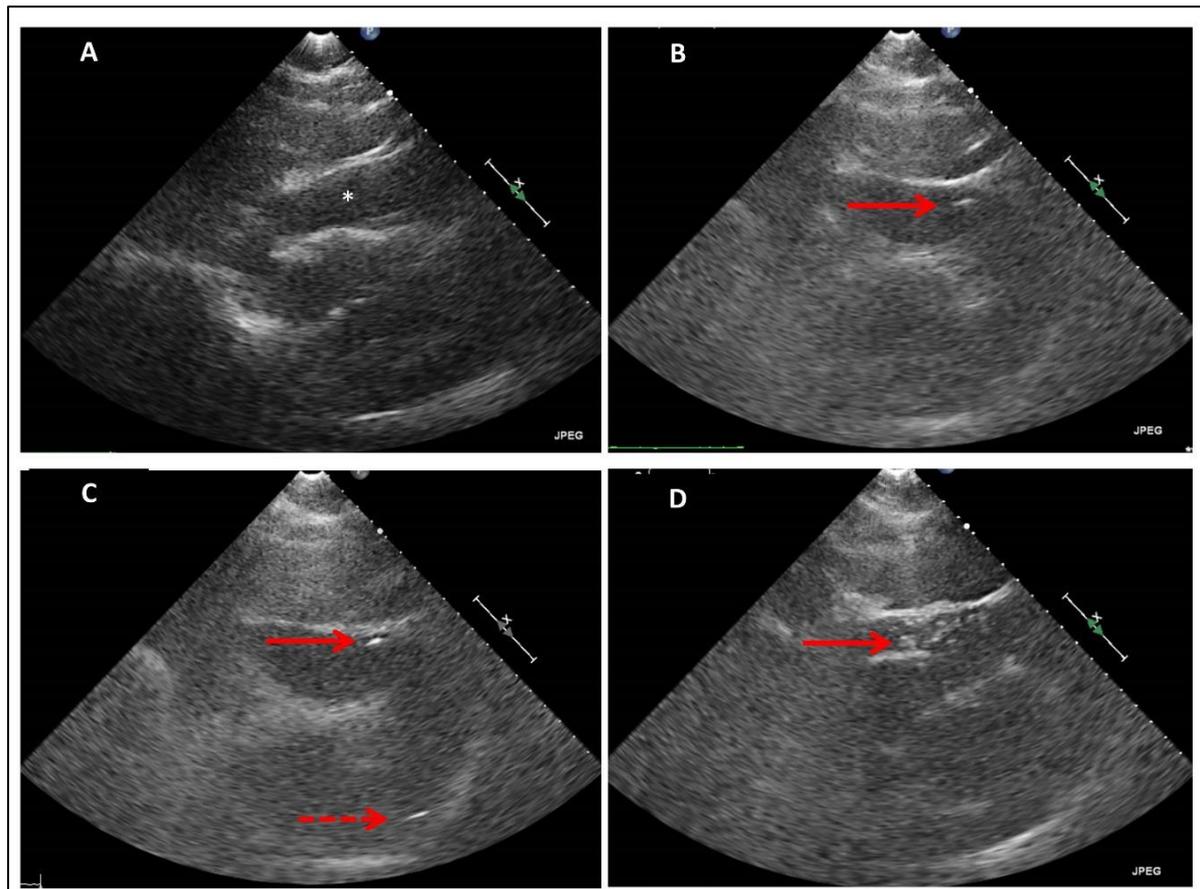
Echocardiograms of echocardiography-assisted pericardiocentesis show (a) subcostal view of a large pericardial effusion (*) with diastolic collapse of the right heart; (b) visualisation of the needle tip (arrow) entering the pericardial space; (c) presence of the needle (solid arrow) and guidewire (broken arrow) within the pericardial space; and (d) presence of echocardiographic bubbles in the pericardial space after injection of agitated saline (arrow) via a dilator.
